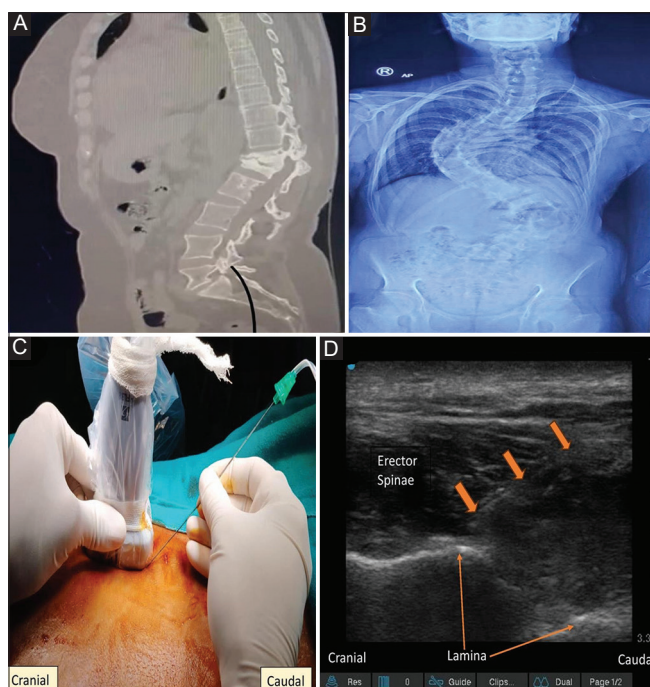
(A) Computed tomography of spine with kyphosis deformity at T12 and L1, (B) X-ray spine showing scoliosis deformity from T1 to L5, (C) needle and ultrasound probe position, (D) sonoanatomy of retrolaminar block
